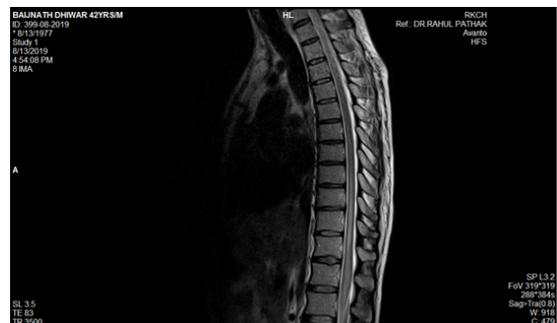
T2 weighted MRI of spine; intramedullary hyperintensity was noted in the spinal cord extending from D8 to Conus.
